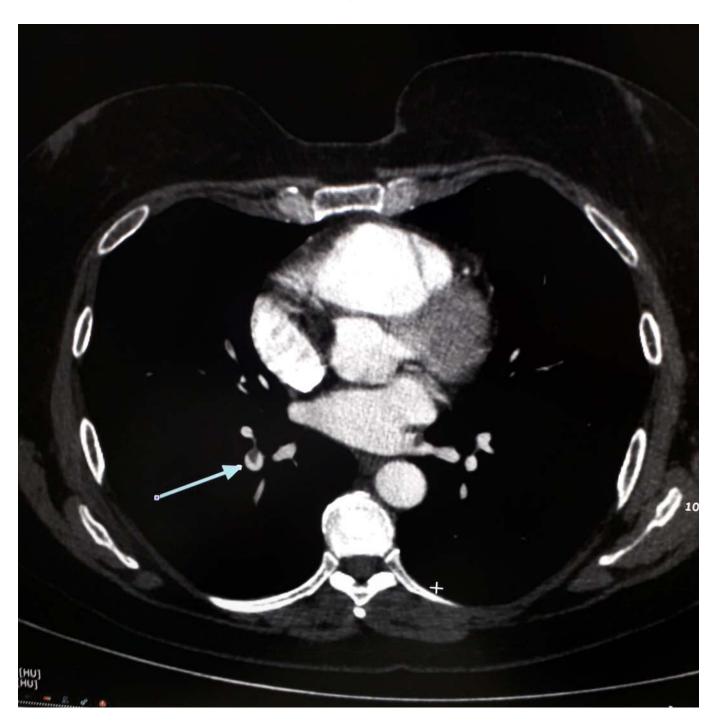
Detail of the pulmonary embolism evidenced by CT scan.
